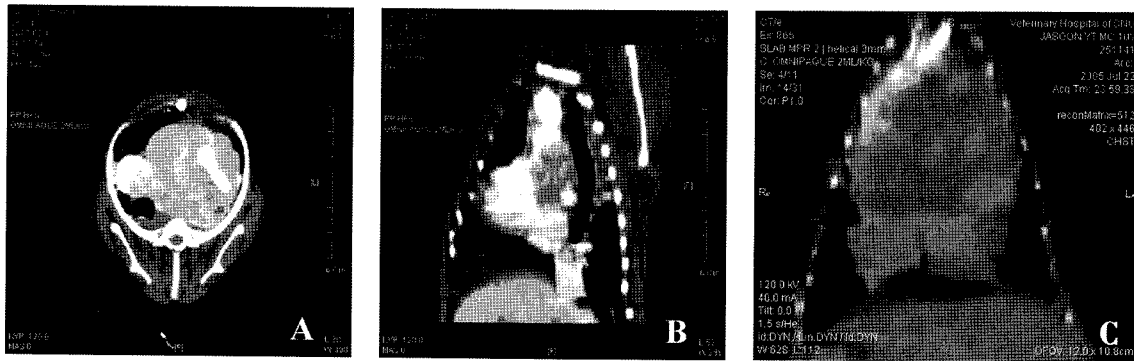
A mass with heterogeneous contrast enhancement, partial invasion and loss of details in the cranial vena cava, right lateral and dorsal displacement of the cranial vena cava and trachea inform a transverse 3.0 mm computed tomogram at the level of the fourth thoracic vertebra (A) and a reformatted image (C), (B) An ill-circumscribed large mass surrounding the aortic region and involvement and dilation of the cranial vena cava from a reconstructive reformatted image.
